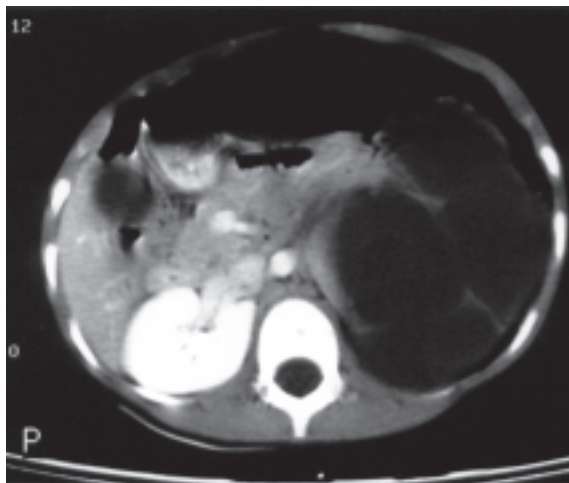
Axial CT scan of the abdomen of a seven-year-old boy shows gross left hydronephrosis from long-standing obstruction.
